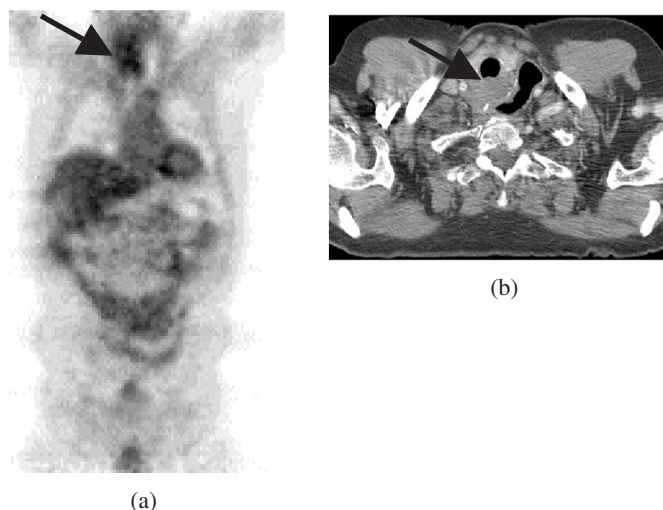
FDG avid, peri-anastomotic recurrent esophageal carcinoma (arrow) at PET (a) and CT (b), 4 years following esophagectomy and gastric pull through.
